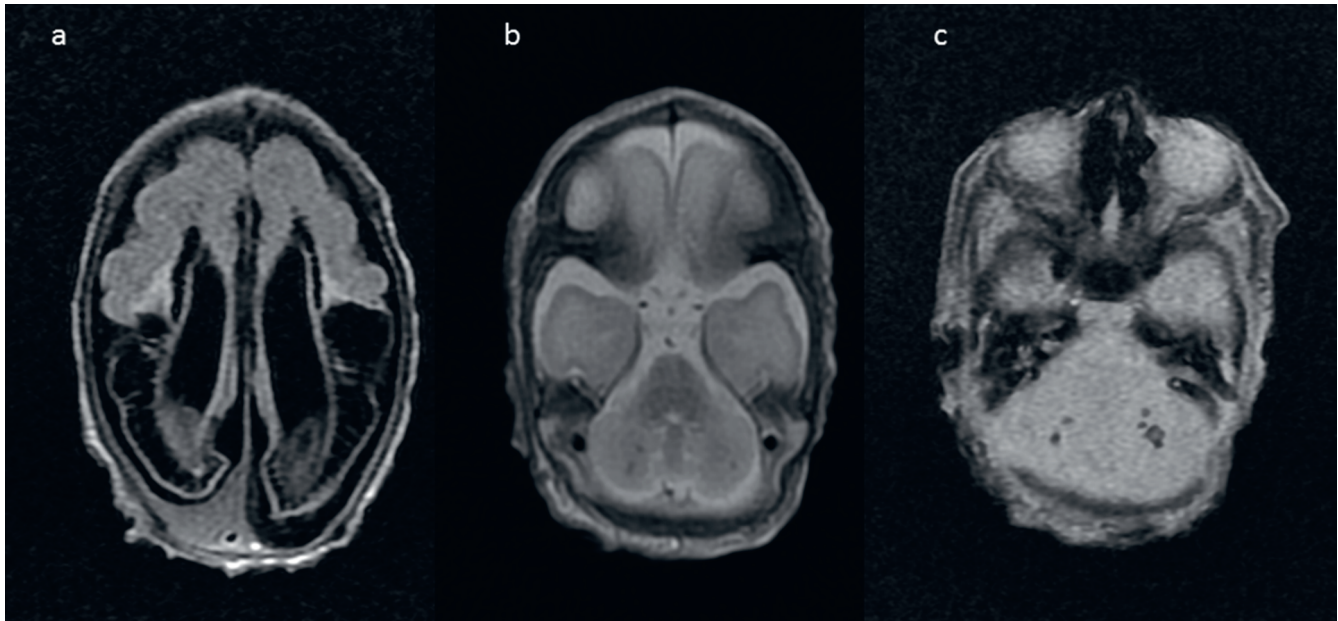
Male preterm neonate born at 26 GW, examined at 29 GW. (a) FLAIR shows relatively small cavities in the frontal lobes and extensive encephalomalacia in the posterior parts of the brain. Pericerebral hematoma on the right. Axial FSE/T2-weighted (b) and GRE/T2*-weighted (c) images show bilateral cerebellar hemorrhages
